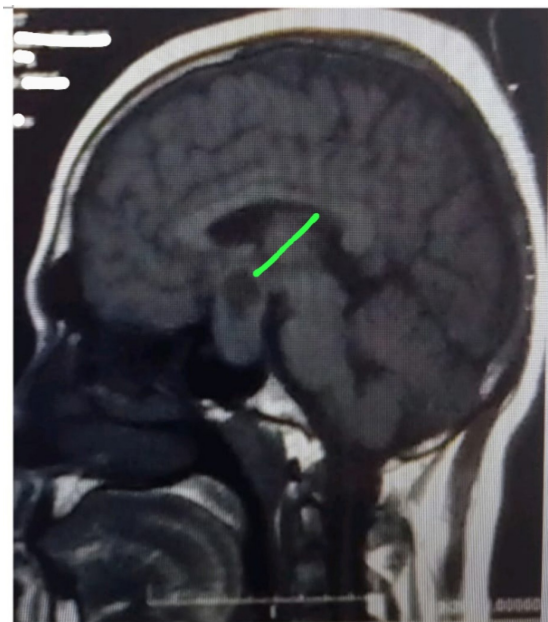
MRI –Suprasellar extension of pituitary macroadenoma
